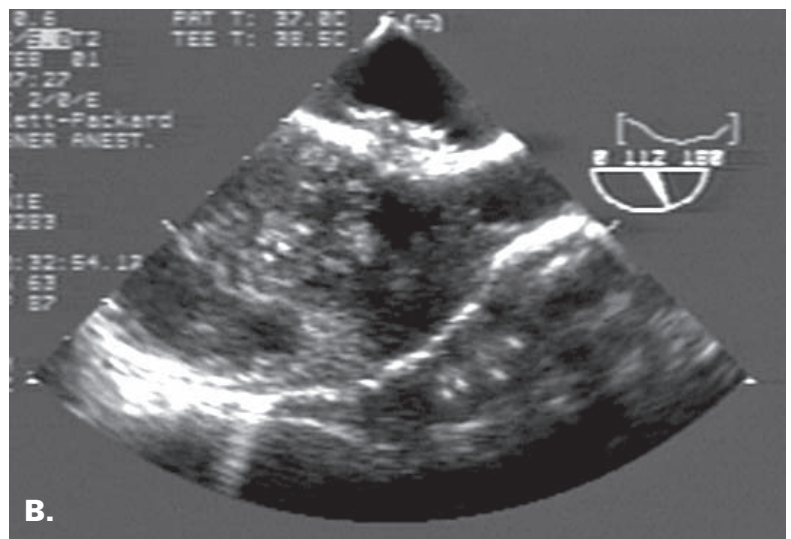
A. Fluoroscopic view of the patent foramen ovale closure device. B. Echocardiographic view of the closure device. Note the contrast bubbles are not crossing into the left heart.
